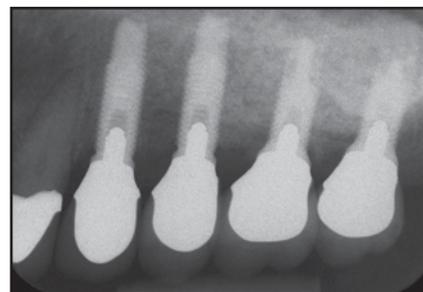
Postoperative radiograph demonstrating precise, prosthetically directed implant positioning outcome.
